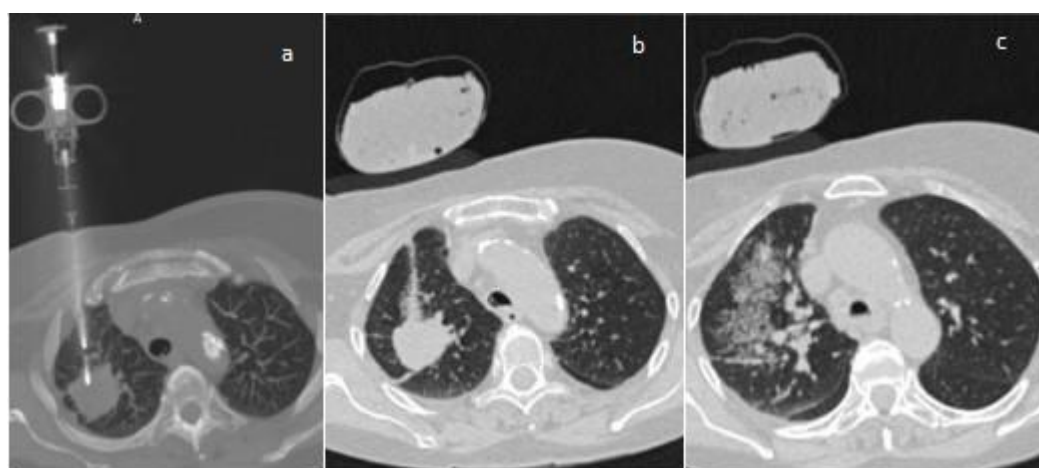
a. CT guided lung biopsy b. linear hemorrhage in needle trajectory c diffuse hemorrhage in lung parenchima
